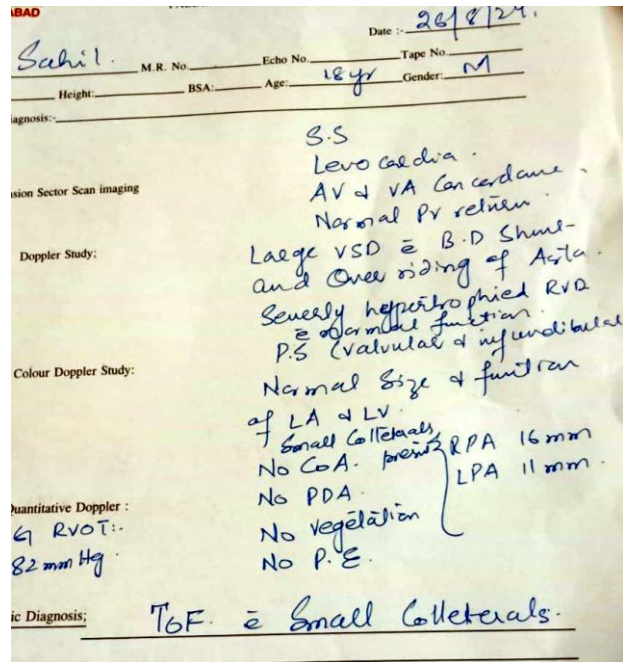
Echocardiography report suggesting Tetralogy of Fallot (TOF)
